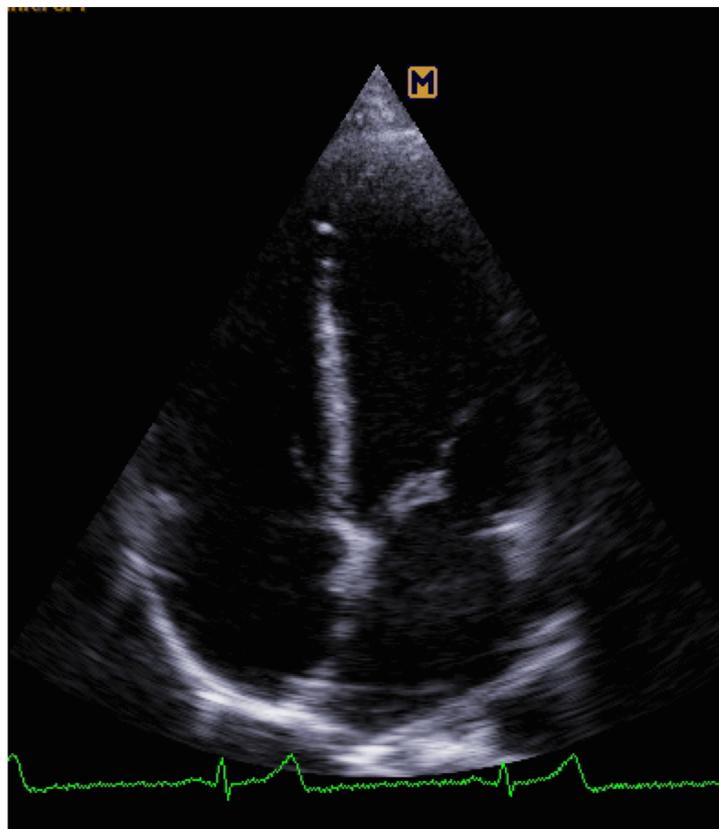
Apical 4-chamber view
